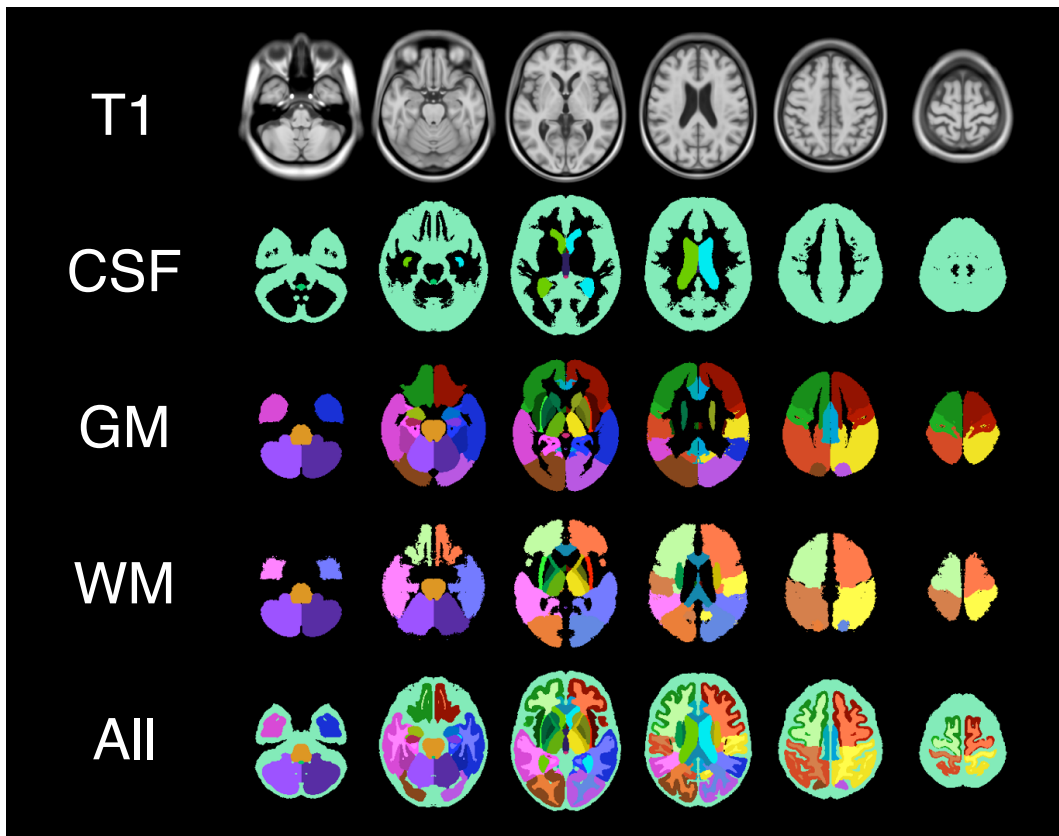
The T1-weighted AGES314 template and the different regional tissue atlases along with the combined regional atlas.
